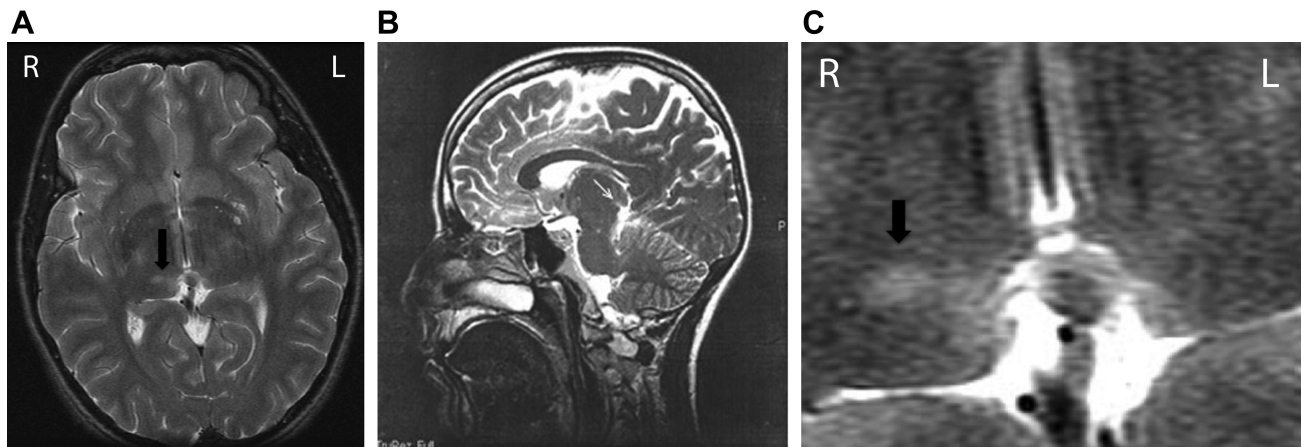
Axial T2-weighted MRI brain showing a hyperintense lesion in the right preteectum and pulvinar, extending from the superior colliculus superolaterally into the posterior-inferior aspect of the right thalamus (arrow) (A). R, right side of brain; L, left side of brain. Sagittal T2-weighted image through the right midbrain showing the small lesion (arrow) at the dorsal (i.e., rostral) border of the superior colliculus close to the posterior commissure (B). Magnified axial T2-weighted MRI image through the region of the hyperintense lesion (arrow), which extends towards the midline (C).
